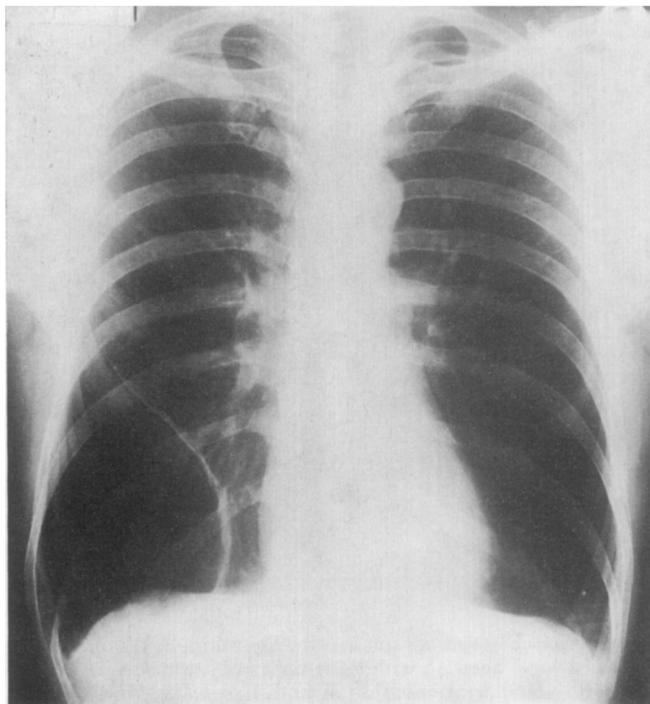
Postero-anterior chest radiograph in full inspiration. The patient was a male aged 50 with  $\alpha_1$ -AT deficiency and emphysema. There is a large bulla in the right lower zone and vascular attenuation at the left base.
